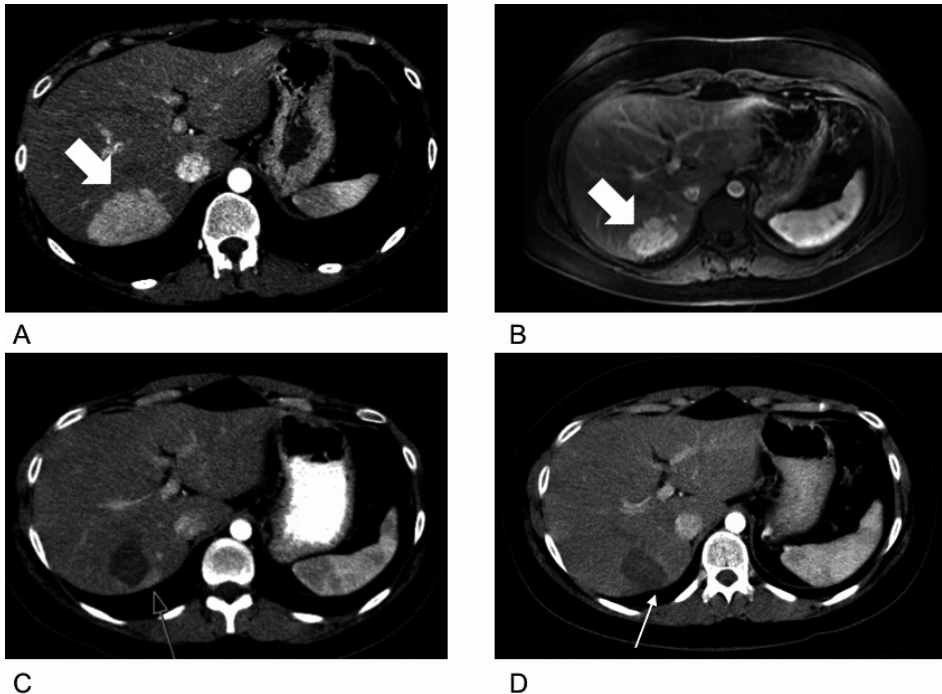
(a) Arterial-phase CT image of a large HCA (arrow) in the posterior segment of the liver in a 22-year-old woman. (b) Contrast-enhanced MR image of the same HCA (arrow) 8 months after cessation of oral contraceptive treatment. (c) Arterial-phase CT image of HCA after incomplete percutaneous RF ablation. Hyperattenuating residual HCA tissue (arrow) is observed at the posterior border of the hypoattenuating RF ablation zone. (d) Arterial-phase CT image of HCA after successful repeat percutaneous ablation. No residual HCA tissue is observed (arrow).
